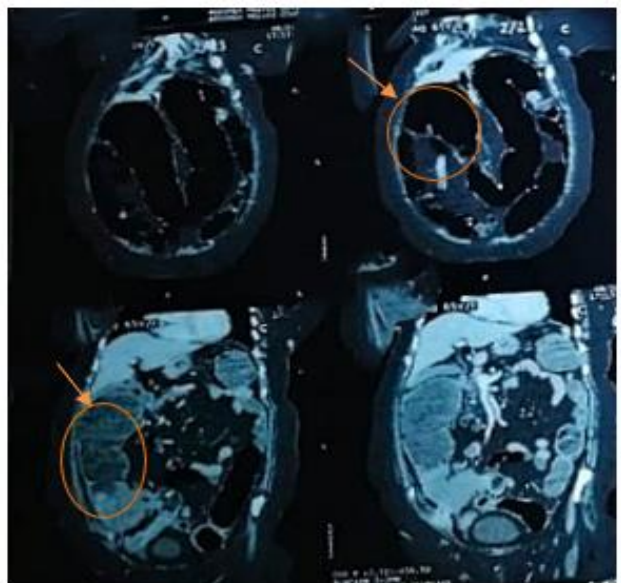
Axial CT abdomen reveals major proximal dilated Gut bowel loops
